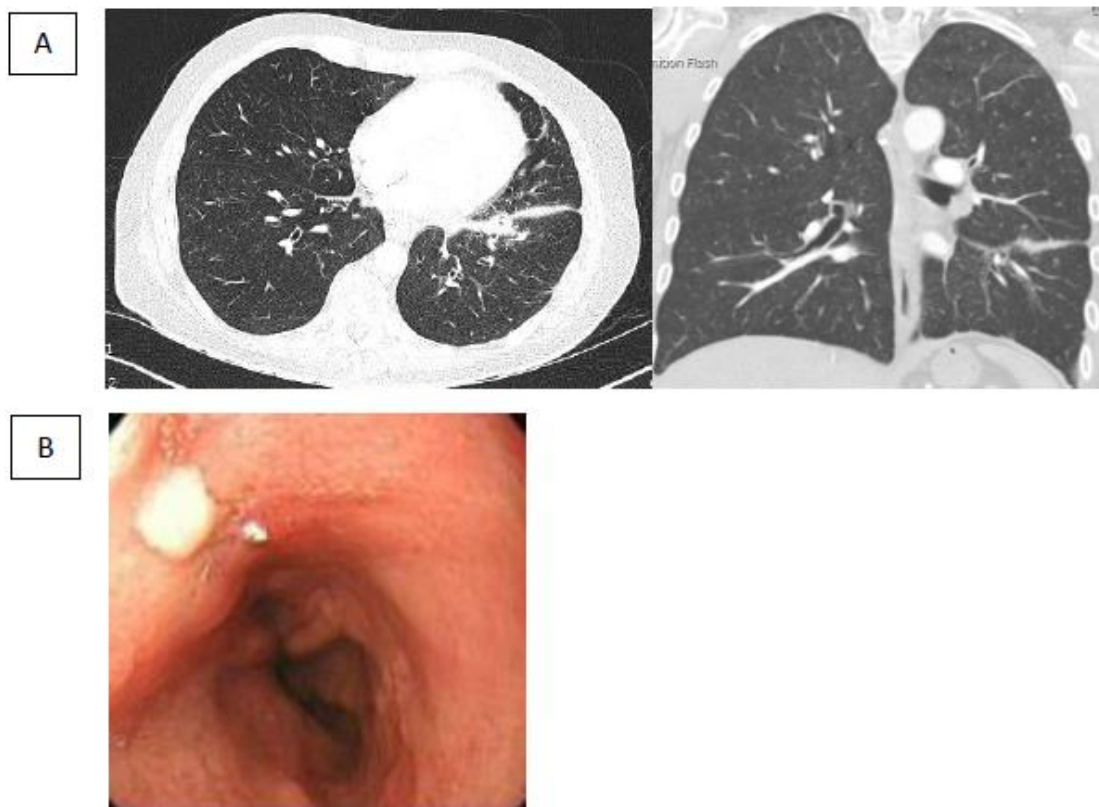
Computed tomographic views of the chest 2 weeks after admission shows the drain which resulted in a remarkably reduction of the empyema [A]. One week after removal of the drain an OGD showed a scar with fibrosis at the position of the earlier defect [B].
